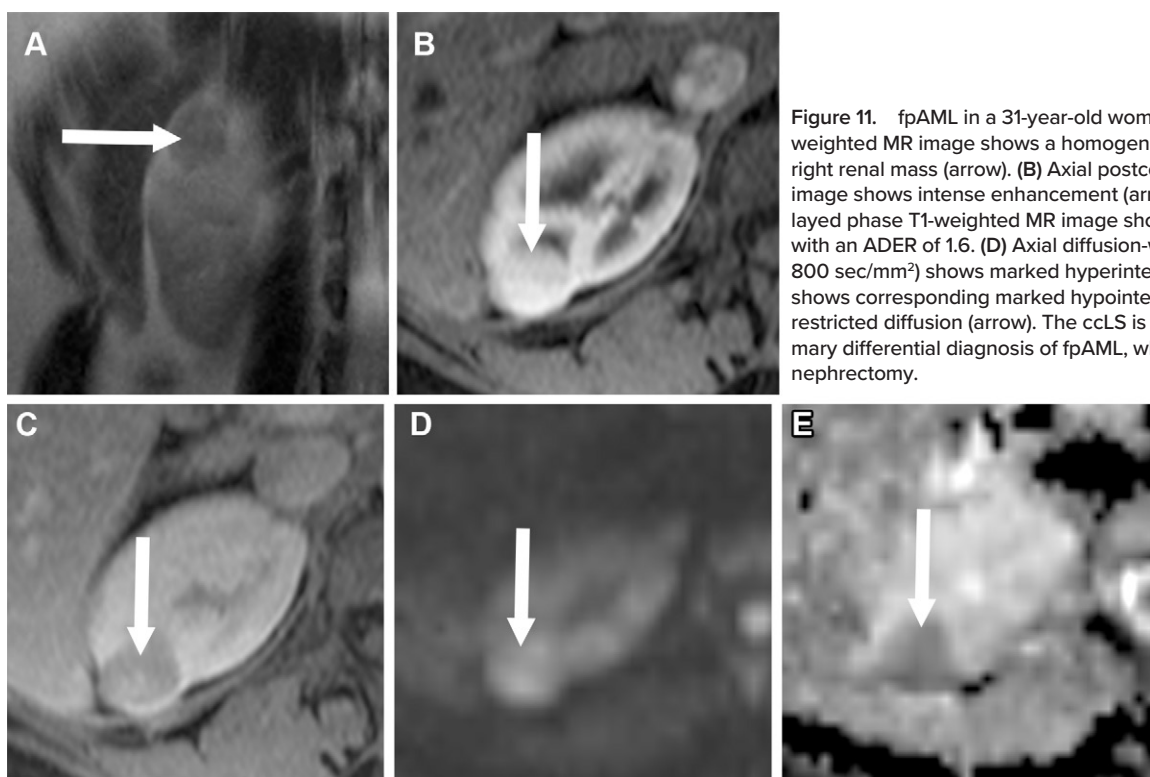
fpAML in a 31-year-old woman with lupus. (A) Coronal T2-weighted MR image shows a homogeneously T2-hypointense 2-cm right renal mass (arrow). (B) Axial postcontrast CMP T1-weighted MR image shows intense enhancement (arrow). (C) Axial postcontrast delayed phase T1-weighted MR image shows hypoenhancement (arrow), with an ADER of 1.6. (D) Axial diffusion-weighted MR image (b value = 800 sec/mm²) shows marked hyperintensity (arrow). (E) Axial ADC map shows corresponding marked hypointensity, consistent with marked restricted diffusion (arrow). The ccLS is 2 (unlikely ccRCC), with a primary differential diagnosis of fpAML, which was confirmed at partial nephrectomy.
